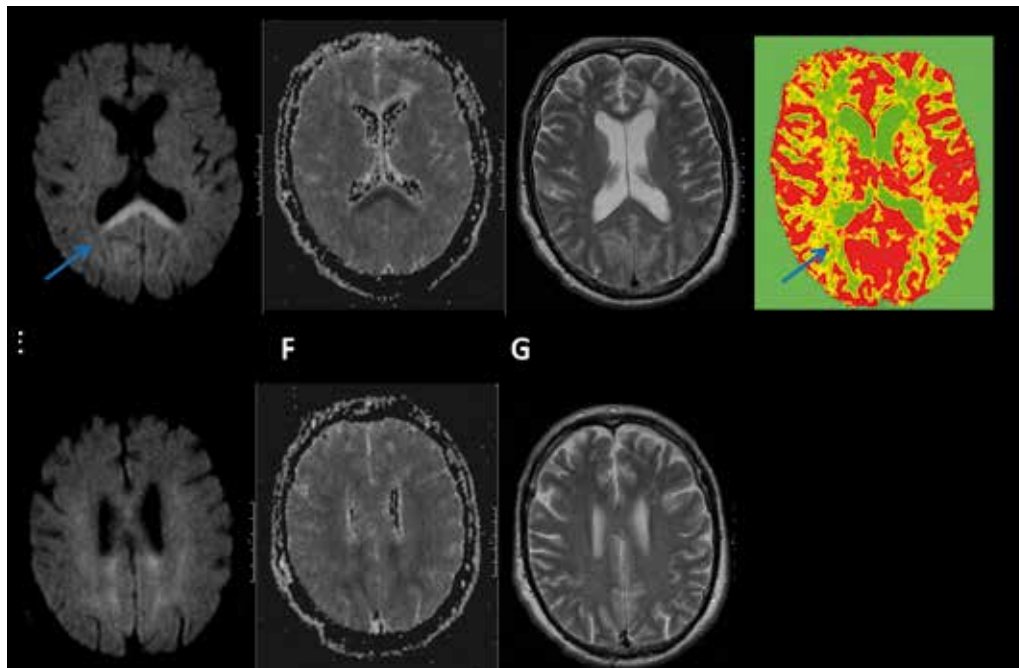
59 year old male with status post myocardial infarct and resuscitation 6 days before MRI with postanoxic (myoclonic) SE, A-C cytotoxic edema in splenium corporis callosi (arrow), D- hyperperfusion bilateral in the cuneus, temporal on the left, and in the corpus callosum (arrow) , E-G cytotoxic edema bilateral mainly in the periventricular white matter, (C/G) Example of a pattern of cytotoxic edema predominant in the white matter tracts correlating to the underlying pathology of cerebral hypoxia due to cardiac arrest. Cross-sectional imaging discloses a diffuse pattern of hyperperfusion including corpus callosum unusual to all other cases reported here. Postanoxic SE is harboring a poor prognosis in a relevant portion of patients. Cross-sectional imaging play a role together with clinical and electrophysiological parameters to estimate prognosis of the underlying pathology (see article from Rossetti and Hänggi et al. in this issue). The experience with perfusion imaging as isolated parameter of epileptic activity is yet limited and to the authors conviction no comment or suggestion can be made at this stage.
